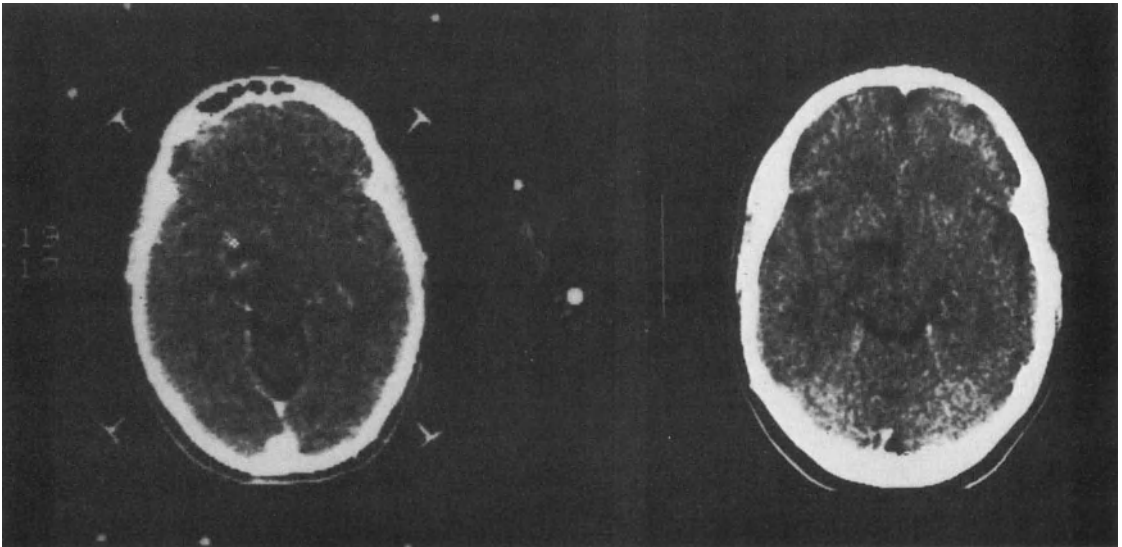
Localization CT scan demonstrates ring enhancing deep left thalamic lesion (*left*). Eleven months later, CT scan shows resolution of the enhancing area surrounding the lesion (*right*).
